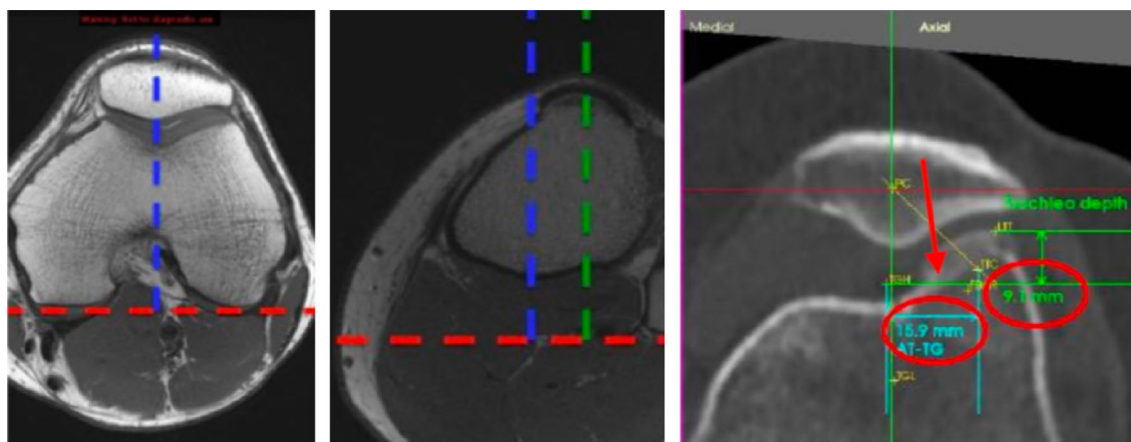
Measurement of TT–TG on CT data as done in this study. a Axial CT scan of the left knee at the level of the femoral epicondyles, showing the perpendicular line meeting the tangent to the posterior condyles and extending through the deepest aspect of the TG. b Axial
